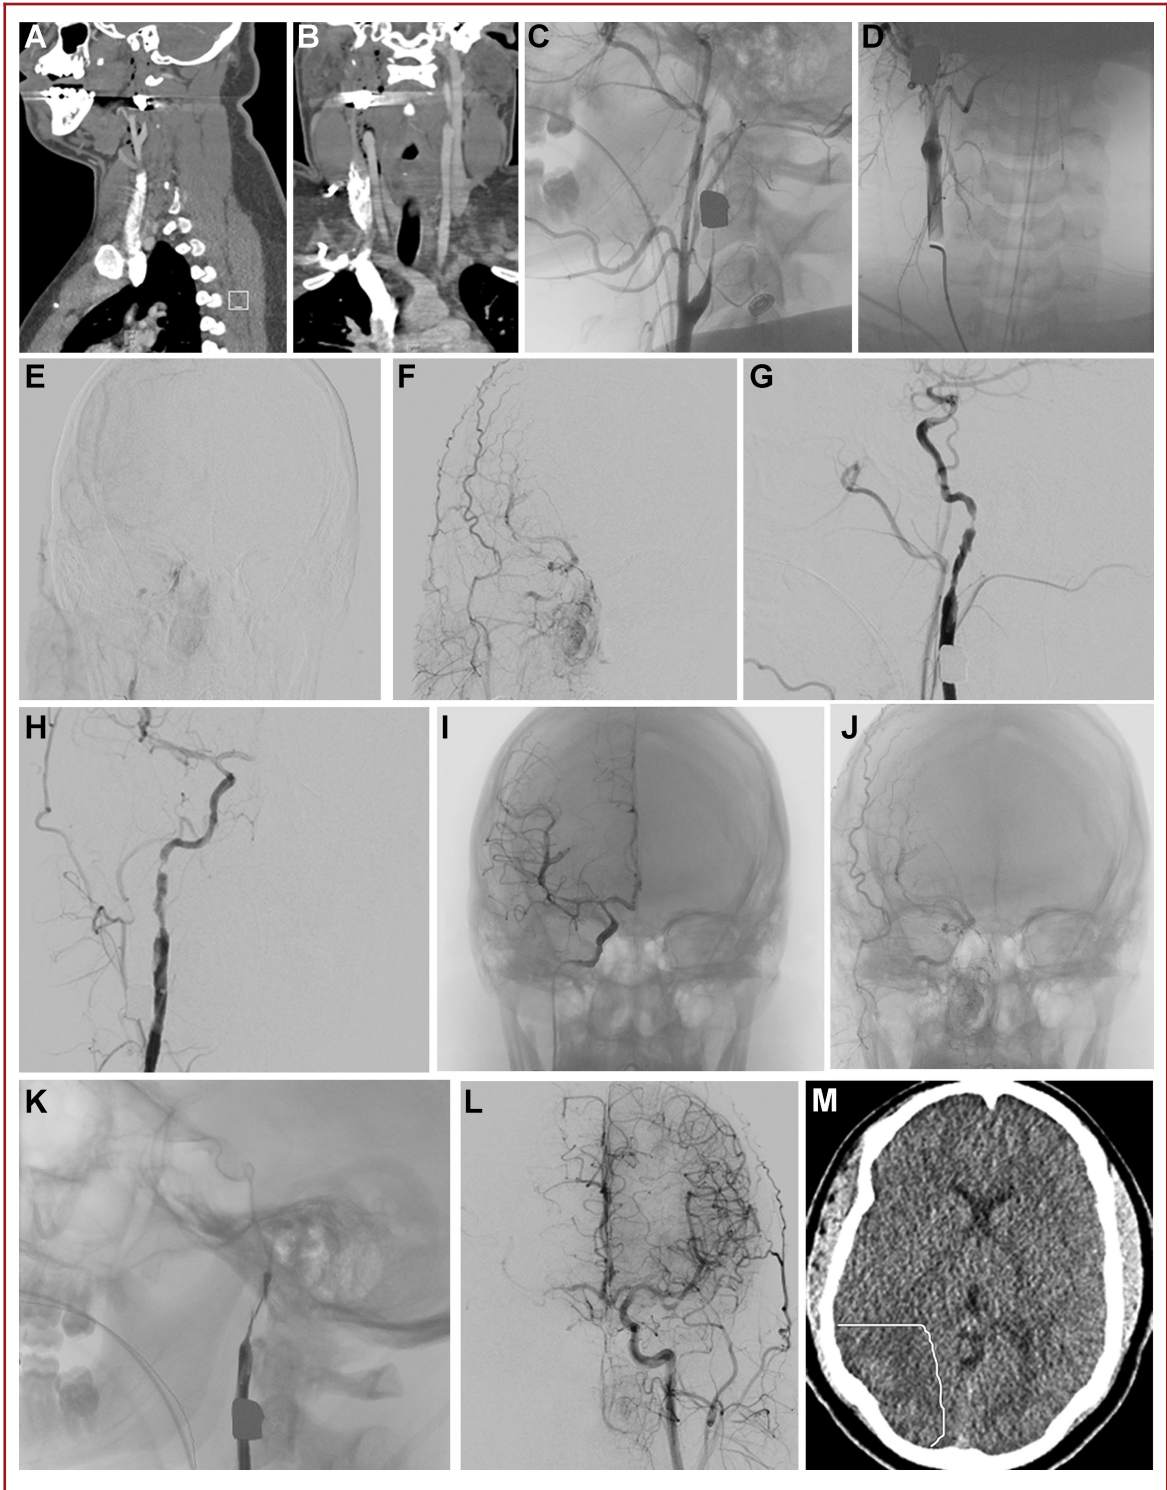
Case 5. A 17-year-old boy who experienced a gunshot wound to the neck. Sagittal A and coronal B CTA of the neck demonstrating occlusion of the right ICA just distal to the bifurcation. Pretreatment lateral C and anteroposterior D cerebral angiogram with right common carotid injection showing occlusion of ICA with preservation of the right external carotid artery. E and F, Pretreatment anteroposterior cerebral angiogram revealing minimal flow in the ICA and minimal flow in the right cerebral hemisphere E with collateral flow provided by the external carotid artery F. Lateral G and anteroposterior H and I cerebral angiogram showing reconstitution of flow through an irregular right ICA after mechanical thrombectomy. Anteroposterior J and lateral K cerebral angiogram showing reocclusion after treatment. Anteroposterior cerebral angiogram with left common carotid artery injection after reocclusion L showing collateral flow to the right middle and anterior cerebral artery distributions. M, Axial head CT taken postprocedurally, approximately 8 h after injury showing possible development of the right-sided watershed cerebral infarction (blue line).
